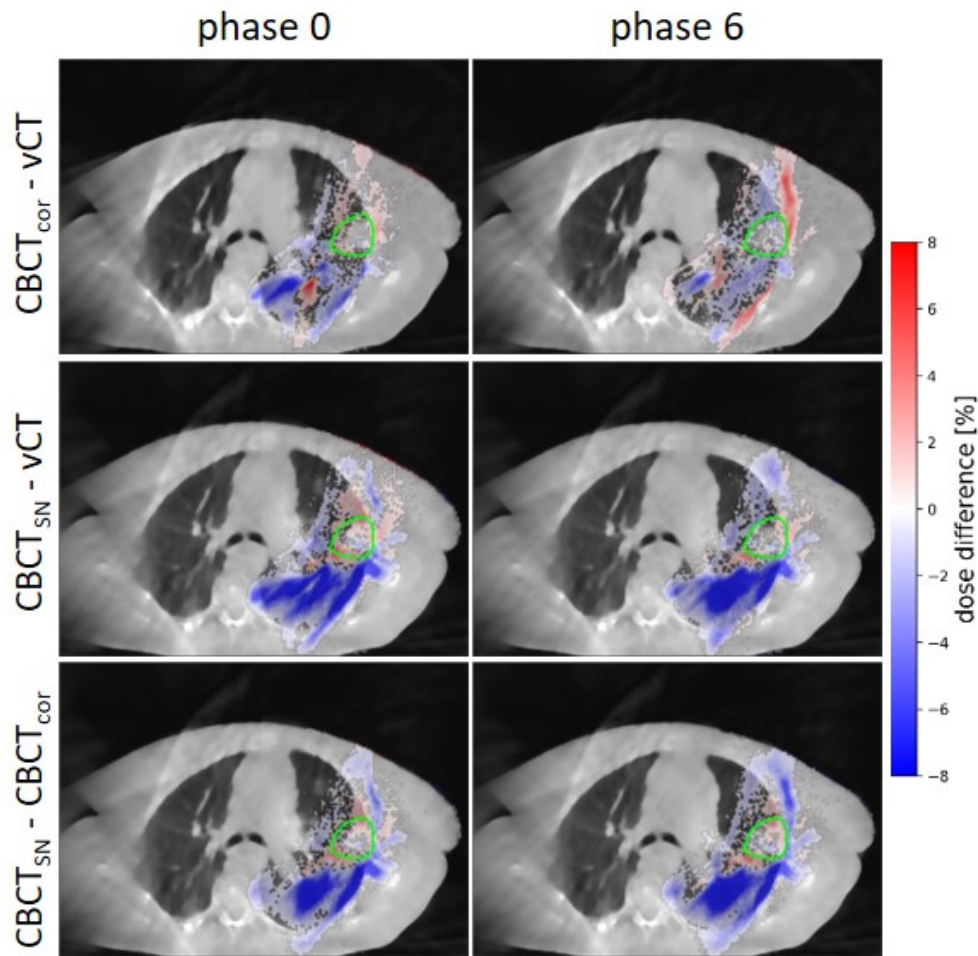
Deviations in percent of the prescribed dose of 60 Gy for the recalculated proton dose distribution of 4DvCT, 4DCBCT_{cor}, and 4DCBCT_{SN} from patient 24. To improve the readability of the plot dose differences smaller than 0.4% are masked.
